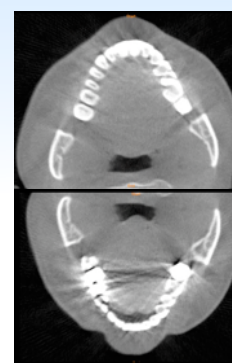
CT image at pre-treatment and post-treatment
